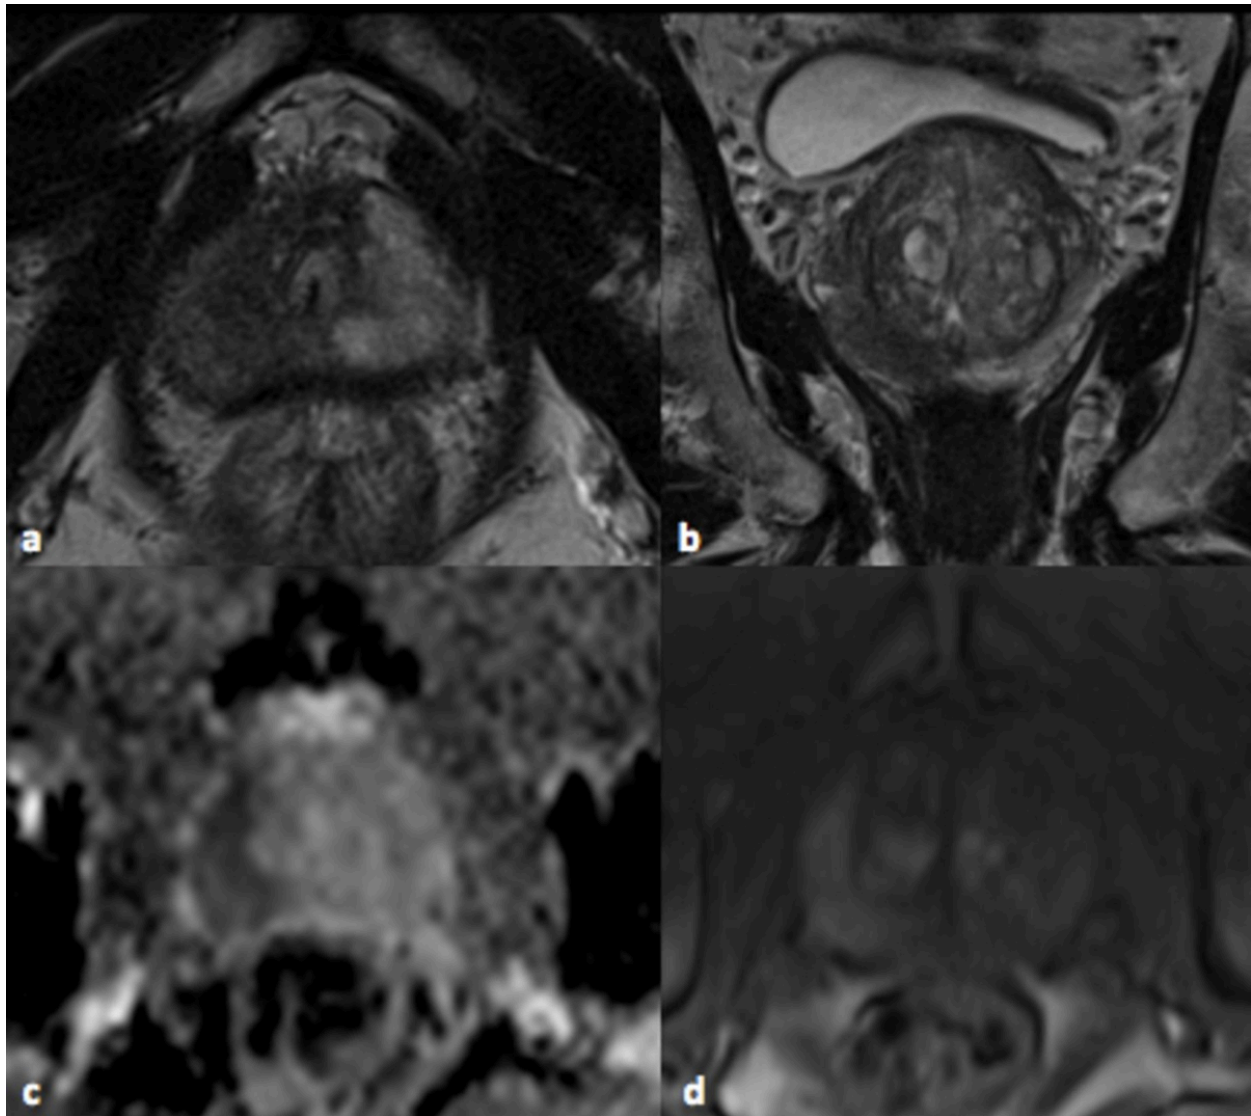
Axial (a) and coronal (b) T2W images: low signal in the peripheral zone on the right. ADC map (c): low signal area in right peripheral zone. Perfusion image (d): high signal area in right peripheral zone. 75 years old, PSA 119 ng/ml. 3 negative random biopsies. Gleason by biopsy oriented by MRI 8 (4+4).
